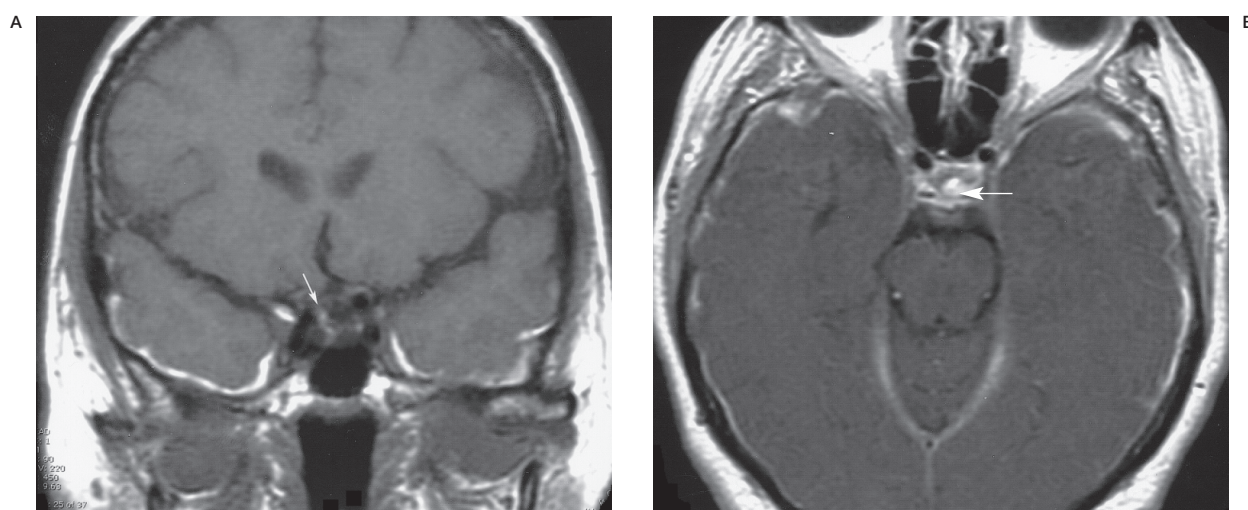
MR images of pure subdural haemorrhage and intrasellar superior hypophyseal artery aneurysm. A) Coronal view T1-weighted image shows subacute blood products (dilute methemoglobin) in the subdural space beneath temporal lobes, flow-void of the dome of a left superior hypophyseal artery aneurysm projecting into the sella turcica, and a small amount of blood adjacent to right side of the dome (arrow). B) Axial view contrast-enhanced T1-weighted image shows enhancement of the aneurysm within the pituitary fossa (arrow).
